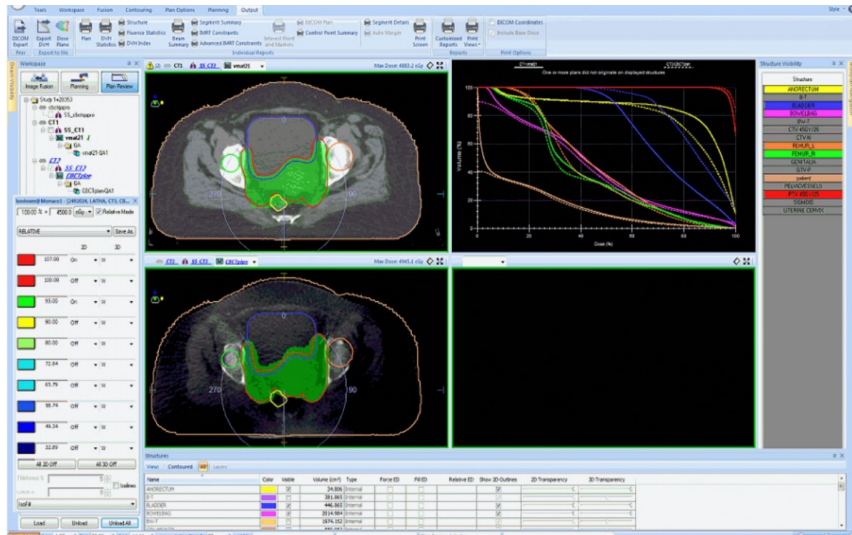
95% Dose Distribution of VMAT Plan in PTV Contour of Both Routine CT and kVCBCT Transverse Images of Cervix Cancer
